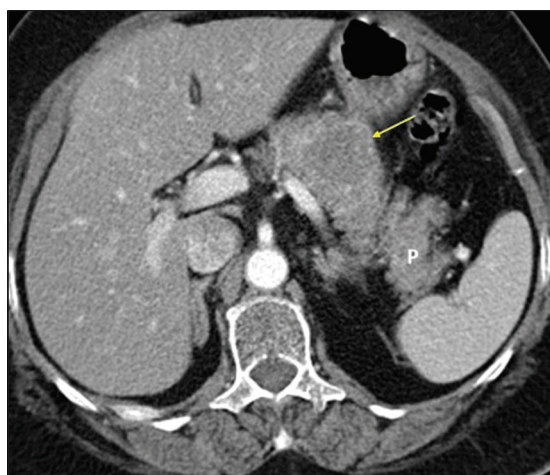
Axial contrast enhanced computed tomography image showing a well-defined heterogeneously enhancing lesion (arrow) in the body of the pancreas (P), suspicious for either a primary pancreatic neoplasm or metastasis
